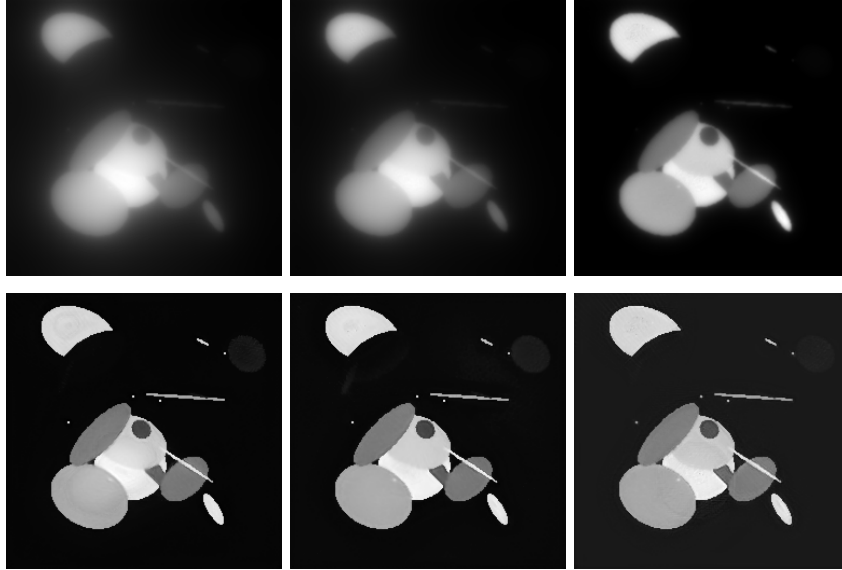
Results on a test image from the COULE synthetic data set, under the $P_{360,360}$ CT protocol. First row, from left to right: x_{RIS} with $K = 3$, $K = 5$ and $K = 10$ respectively; second row, from left to right: the corresponding x_{RISING} .
